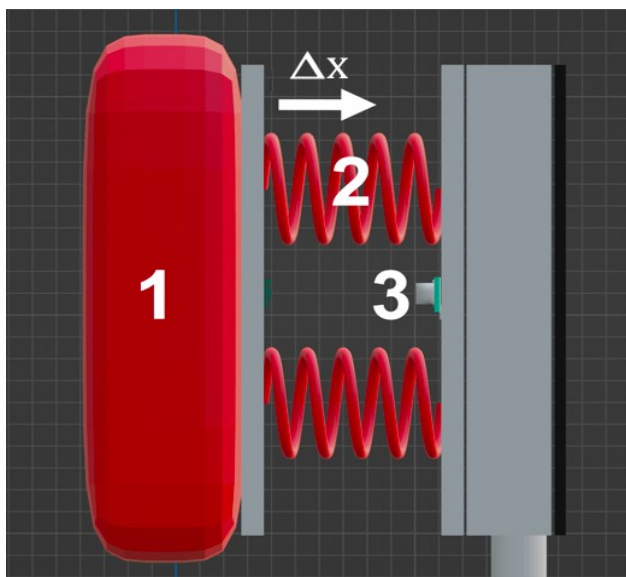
Construction of punching bag, springs, and ultrasonic sensor
